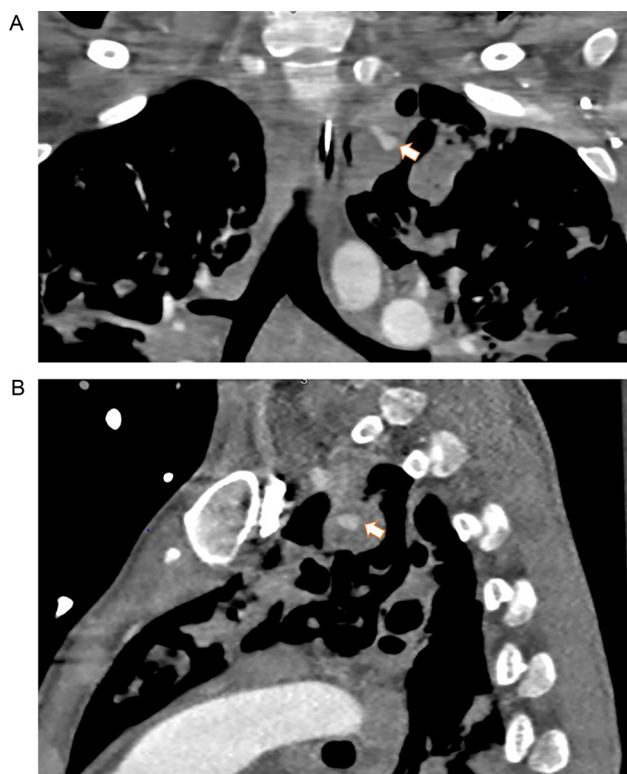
(A-B) Repeat CT angiogram of the chest at the time of re-representation, 11 days after the original study. Coronal (Fig. 3A) and sagittal (Fig. 3B) sequences demonstrate grossly similar opacification the pseudoaneurysm (arrow), but now with increased soft tissue nodularity, and increased opacifications throughout the lung fields.
